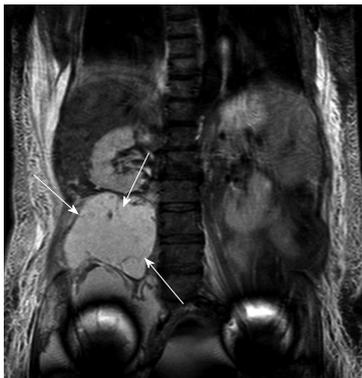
A 58-year-old patient with bilateral large diameter total hip replacement metal-on-metal implanted 9-years ago, moderate hip symptoms and raised metal ion levels (Cobalt 17 ppb, Chromium 13 ppb). She presented to the general surgeons with abdominal pain and distension. Coronal magnetic resonance imaging scan (above) demonstrated a large cystic pseudotumour extending into the pelvis up to the level of the L2 vertebra and abutting the right kidney in the retroperitoneal space (arrows). The cystic pseudotumour was drained prior to surgical excision with both orthopaedic and vascular surgeons present.
